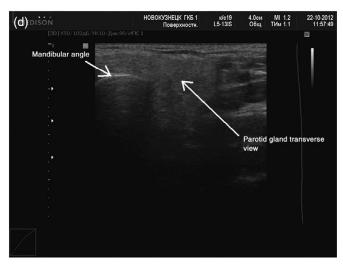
The parotid gland under ultrasound. The presentation depends on the position of the probe. (a,b). Probe in the vertical position (a) to give a longitudinal view of the parotid (b). (c,d) Probe in the horizontal position (c) to give a transverse view of the parotid (d).
